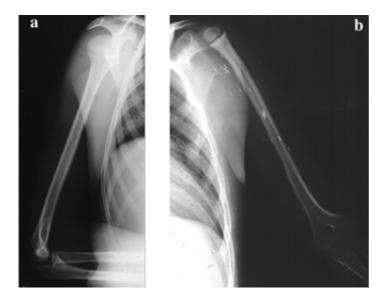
Radiograph at 3 years follow-up showing remodelling of the fibular head (a) compared to opposite humerus (b)
